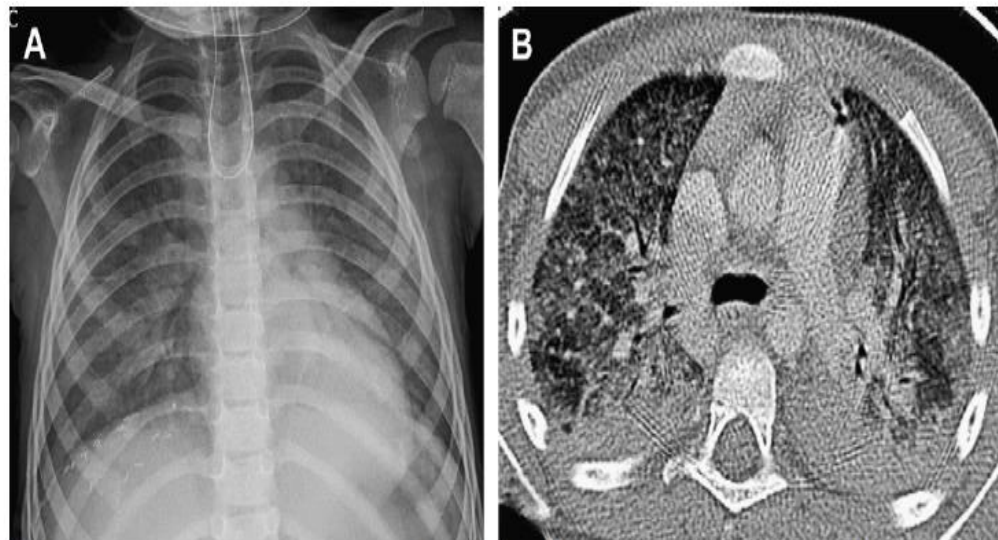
Pneumocystis jiroveci* pneumonia in a 4-year-old girl 2 years after liver transplant with known posttransplant lymphoproliferative disorder. (A) Frontal chest radiograph shows diffuse bilateral ground-glass opacities and malpositioned nasogastric tube coiled in the esophagus. (B) Axial contrast-enhanced CT shows bilateral diffuse ground-glass opacities and dependent atelectasis.
